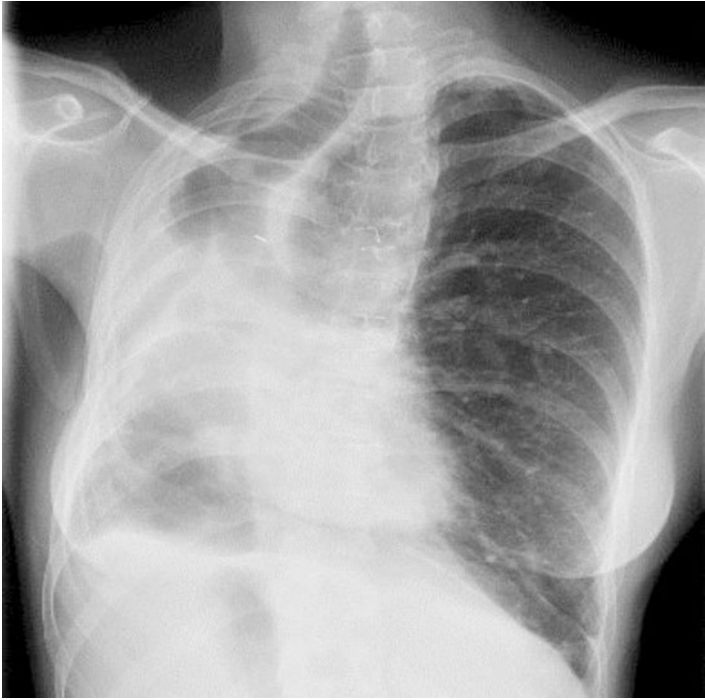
Chest X-ray in a patient with dextrocardia due to right pneumonectomy. The cardiac apex is pointing toward left, but the cardiac silhouette and bronchus are seen on the right side of the sternum
